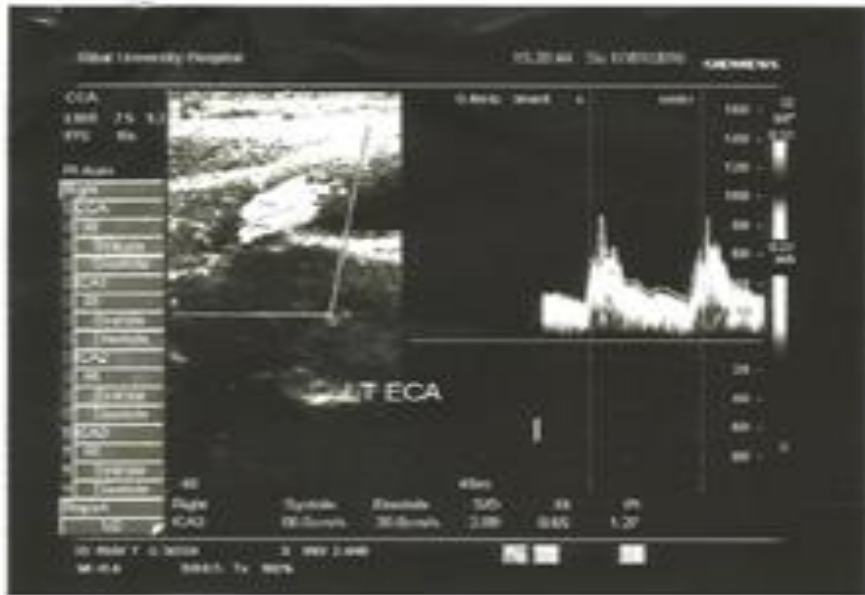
Rt ICA-female- 65 years diabetic patient with normal Doppler parameters.
